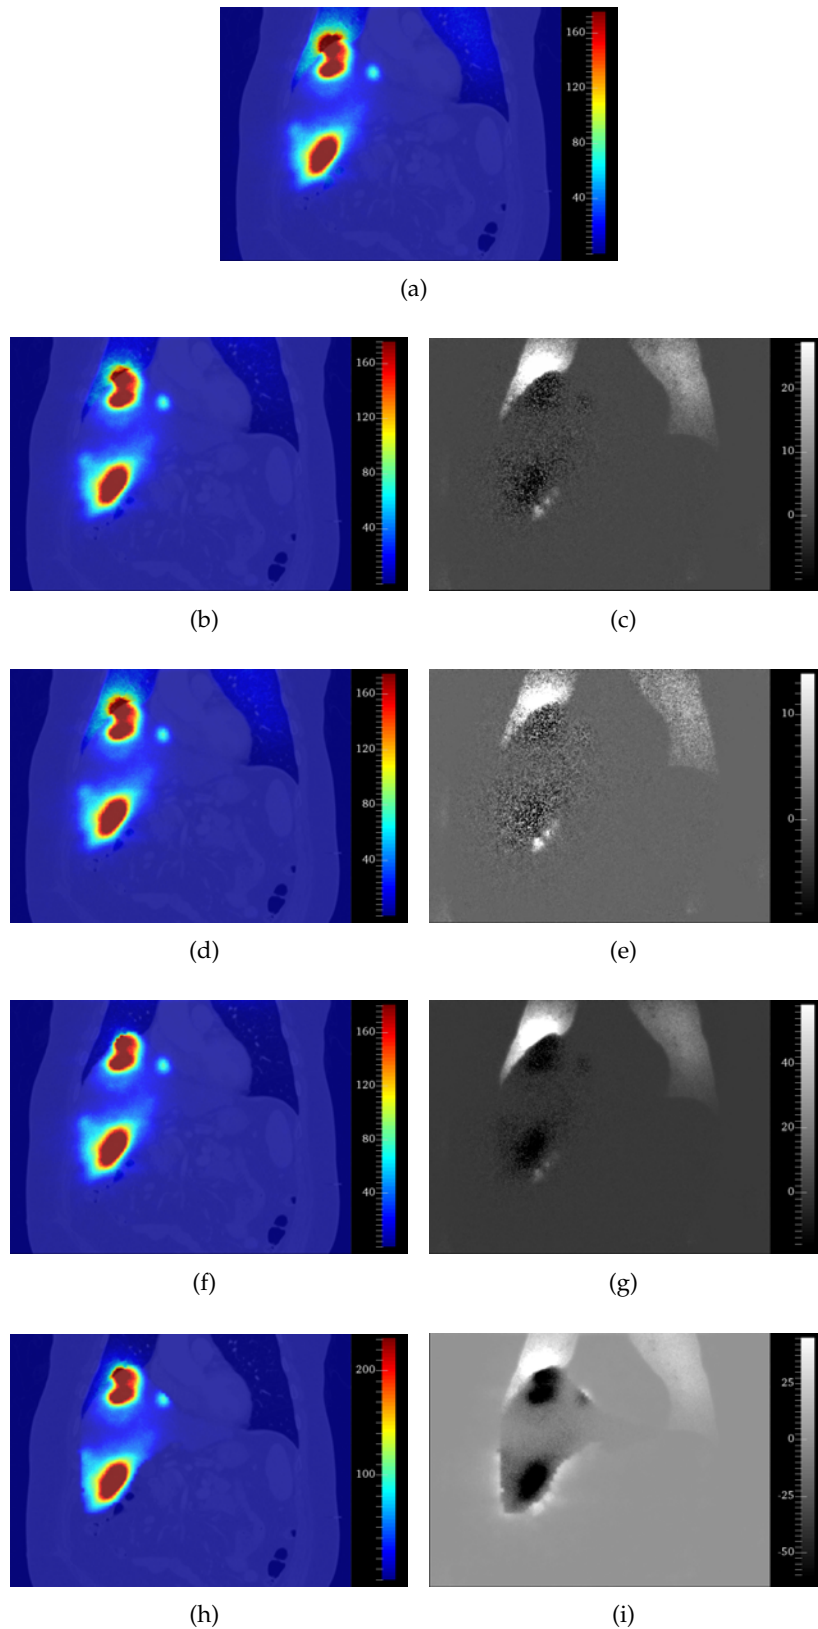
Coronal fusion slices for patient 2 of CT and GATE absorbed dose maps (Gy) obtained with native- (a) and filtered-SPECT A (b), B (d), C (f) and D (h) (Sec. 6.3.2), each accompanied on its right by the corresponding difference image (Gy) between native- and filtered-SPECT absorbed dose maps.
